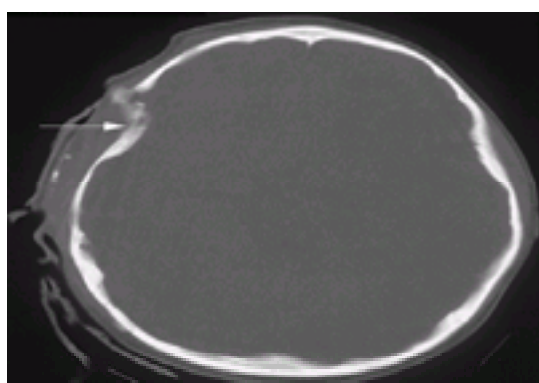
Depressed skull fracture. This head computed tomography (CT) scan was performed on a 6-year-old boy who was unresponsive and apneic after being a passenger in a high-speed motor vehicle collision. The *arrow* indicates a depressed skull fracture involving the right temporal bone. He also had an associated right temporal contusion (see [Fig. 105.7](#)).
